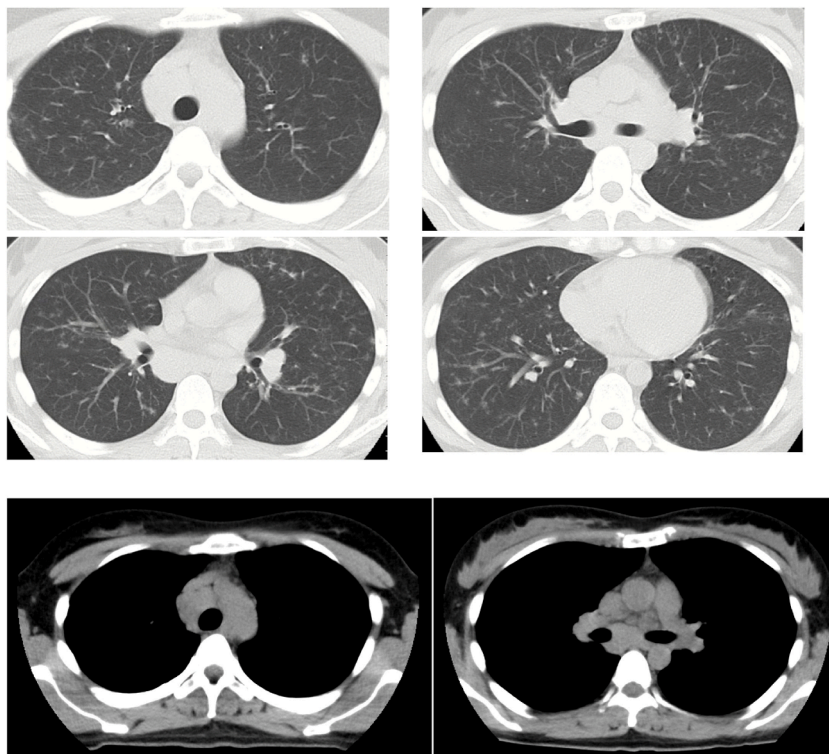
CT images at the first presentation.
